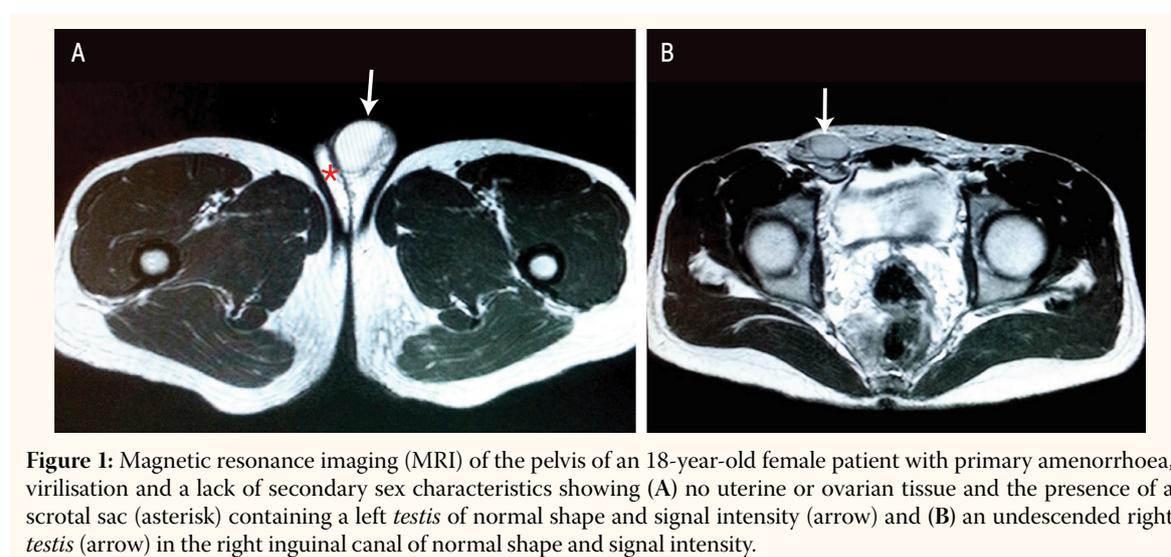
Magnetic resonance imaging (MRI) of the pelvis of an 18-year-old female patient with primary amenorrhoea, virilisation and a lack of secondary sex characteristics showing (A) no uterine or ovarian tissue and the presence of a scrotal sac (asterisk) containing a left *testis* of normal shape and signal intensity (arrow) and (B) an undescended right *testis* (arrow) in the right inguinal canal of normal shape and signal intensity.
